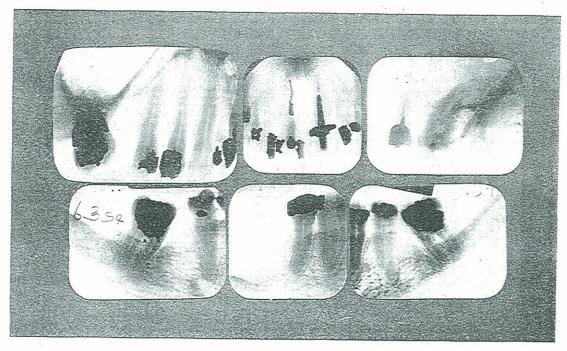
ROENTGENOGRAPHIC APPEARANCE OF DENTAL CONDITIONS OF VERY SEVERE CASE OF EXOPHTHALMIC GOITER WITH HEART INVOLVEMENT. PATIENT VERY RAPIDLY RECOVERED AFTER REMOVAL OF THE DENTAL INFECTIONS. CASE 471.
